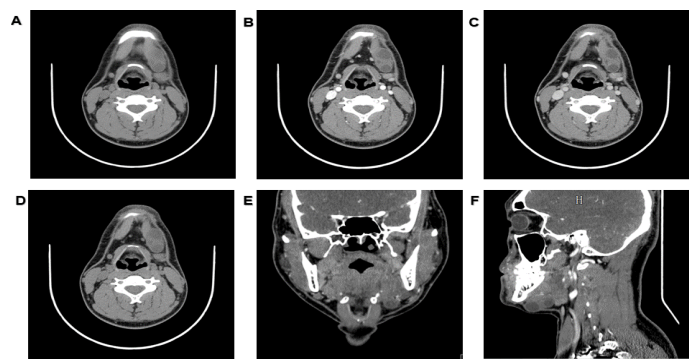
Computed tomography shows the ranula lesion extending from the right submandibular space through the plane of the mylohyoid. This mass was approximately 50 mm in diameters. A) Routine scan; B) Arterial phase; C) Venous phase; D) Delayed phase; E) Coronal position (arterial phase) and F) Sagittal position (arterial phase).
